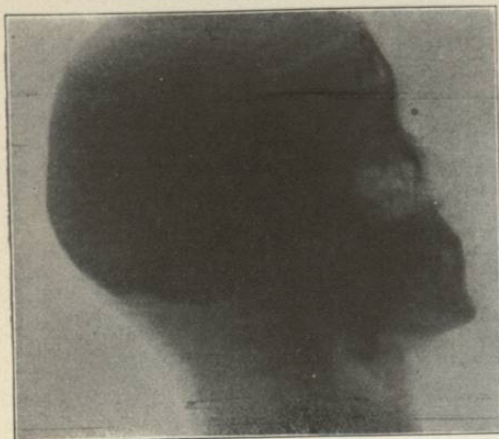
Radiograph. Case of G. W. G.—, showing leaden slug lodged in base of tongue. The ball entered behind the left ear. Radiograph taken fourteen months after injury. Remote effects: left hemiparalysis of tongue, also loss of taste on left side; loss of hearing in left ear; left optic neuritis; partial ankylosis of lower jaw and painful deglutition.
